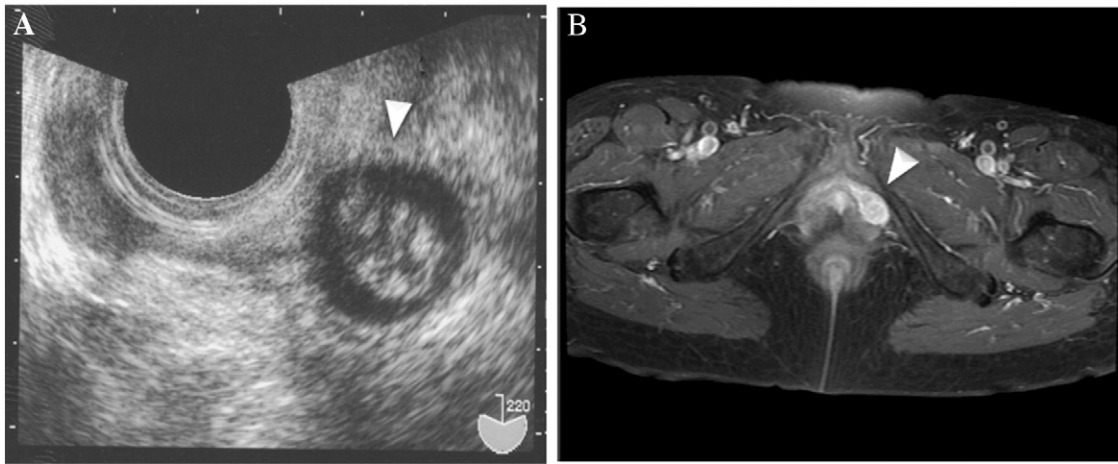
A: Transvaginal ultrasonography. 3.2×2.0 cm low echo area with an irregular internal pattern was observed at the left side of the vaginal ostium. B: MRI of the pelvic cavity. 2.0×1.9 cm mass imaged with contrast enhancement corresponded to the left Bartholin's gland. The border with adjacent bone was clear.
